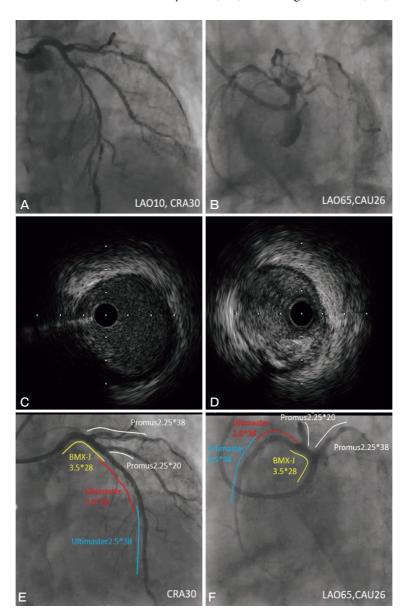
A, Angiography findings of the left coronary artery (LCA) before the initial percutaneous coronary intervention (PCI); C, Intravascular ultrasound (IVUS) showed that plaque was not evident in the left main trunk (LMT) ostium; D, IVUS showed a moderate amount of plaque at the left anterior descending artery (LAD) ostium. Final angiography of the initial LCA PCI. Diagonal branch; (DB), Promus Element,  $2.25 \times 20$  mm (Boston Scientific, Natick, MA, USA); Distal LAD, Ultimaster,  $2.5 \times 38$  mm (Terumo); High lateral (HL), Promus Element,  $2.25 \times 38$  mm (Boston Scientific); LMT ostium to the LAD, BMX-J,  $3.5 \times 28$  mm (Terumo); Mid-LAD, Ultimaster,  $3.0 \times$ 38 mm (Terumo) (E, F).
